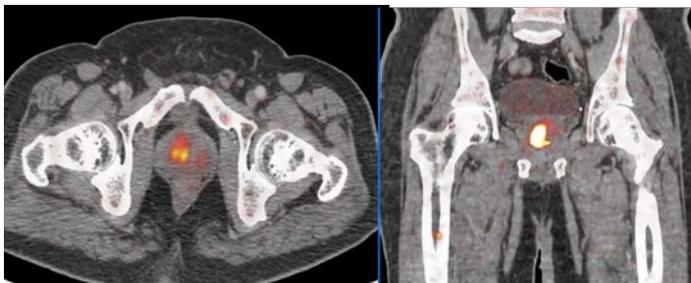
(A) & (B): Recurrent adenocarcinoma prostate. Transaxial and coronal sections of pelvis in a 74 yrs old male with hypermetabolic PSMA avid lesion in prostate. No other PSMA avid lesion in rest of the body.
